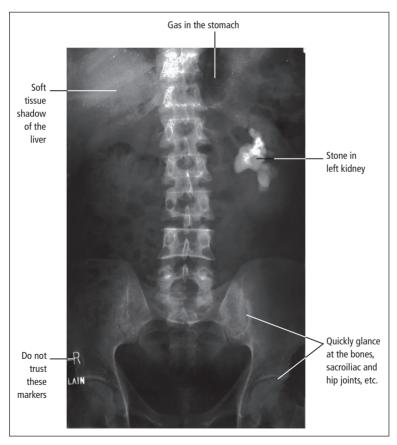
Check the plain abdominal X-ray for the four Ss: side, skeleton, soft tissues and stones.
